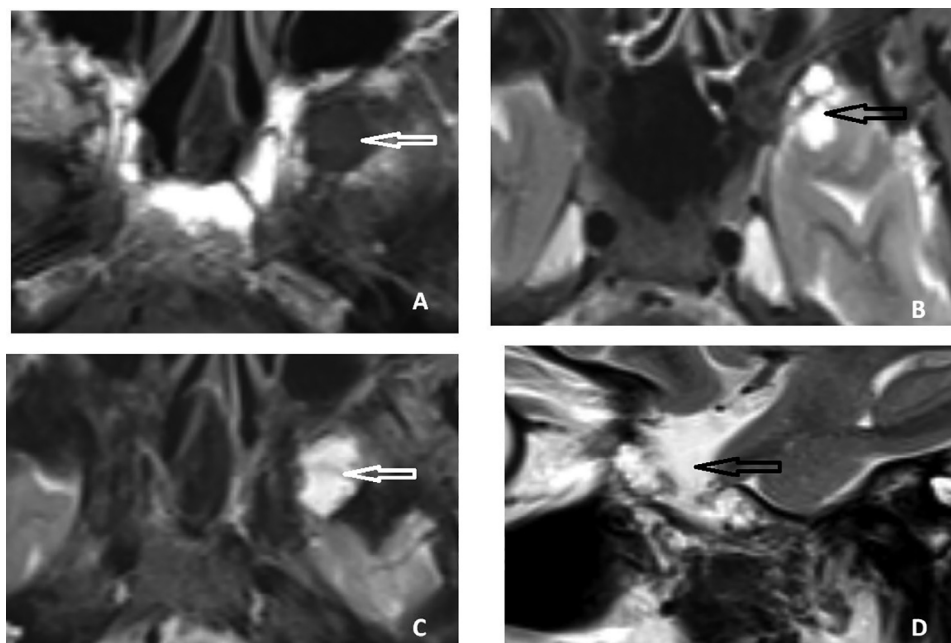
Magnetic resonance images. Axial T1-weighted (A), axial T2-weighted (B and C), and sagittal T2-weighted (D) images demonstrate the intradiploic simple multiloculated cystic lesion of the left greater wing of the sphenoid (arrows), communicating with the small intracranial arachnoid cyst.
